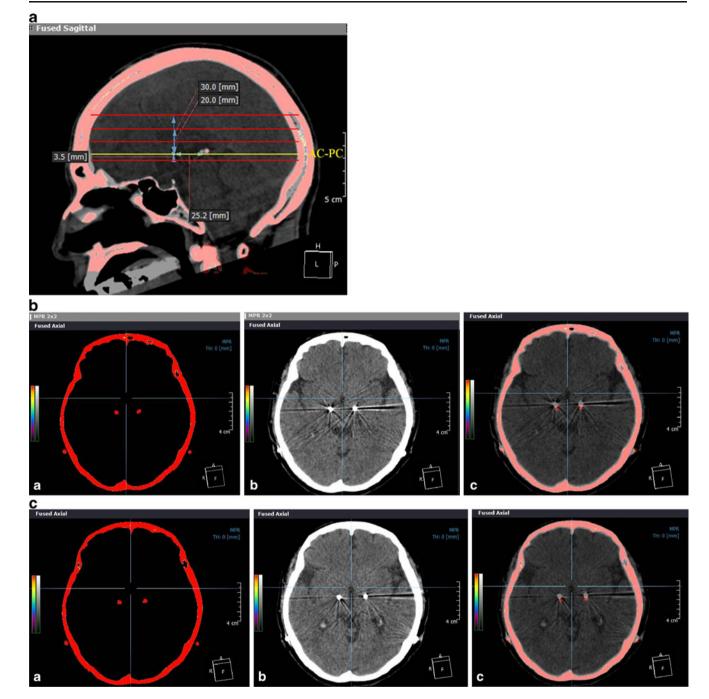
The comparisons of electrode positions at five different sites between the immediate postoperative brain CT and the brain CT taken 6 months after bilateral STN DBS. After image fusion by using the mutual information technique, the marked discrepancy of electrode positions is shown distinctly. a The sagittal view of fused image of the immediate postoperative brain CT (*red*) and the brain CT taken 6 months after surgery showing the AC–PC line (*horizontal yellow line*), and the five levels are marked in *horizontal red lines*. b The axial view at the lowest level, 3.5 mm below the AC–PC line, where the subthalamic nucleus is well visualized along with the red nucleus and putamen. (*a*) Immediate postoperative brain CT in *red*. (*b*) Brain CT taken 6 months later. (*c*) Fused image of (*a*) and (*b*). c The axial view at the level of the AC–PC line, where the putamen is well visualized; (*a*) immediate postoperative brain CT in *red*; (*b*) brain CT
